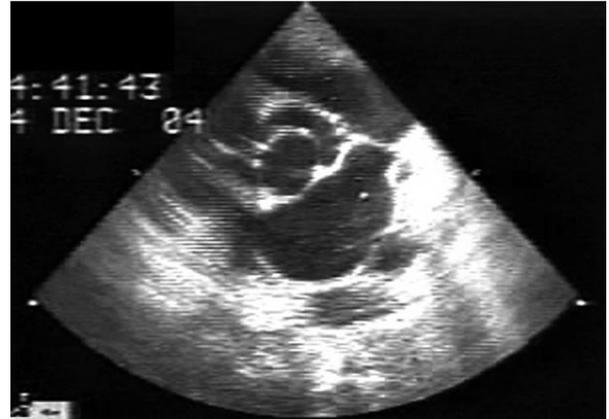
Parasternal short axis view shows the bicuspid aortic valve.
